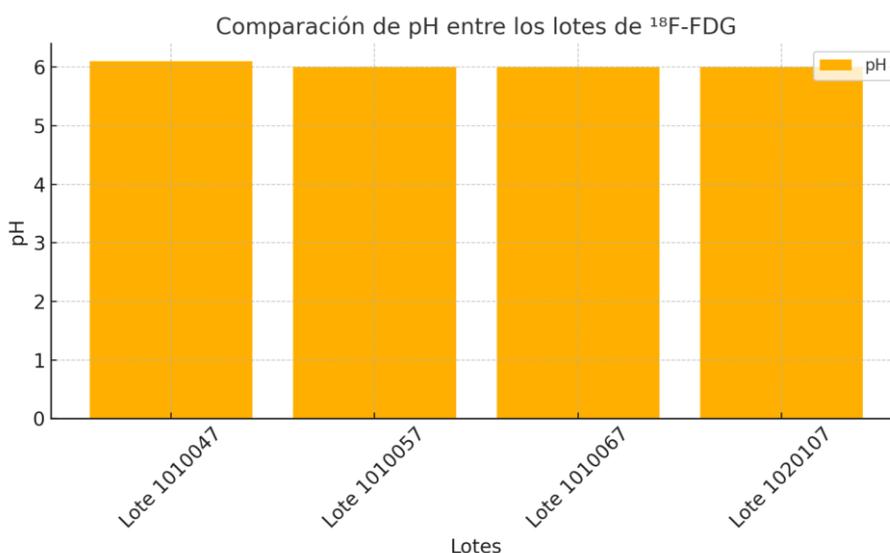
pH comparison between ^{18}F -FDG batches
